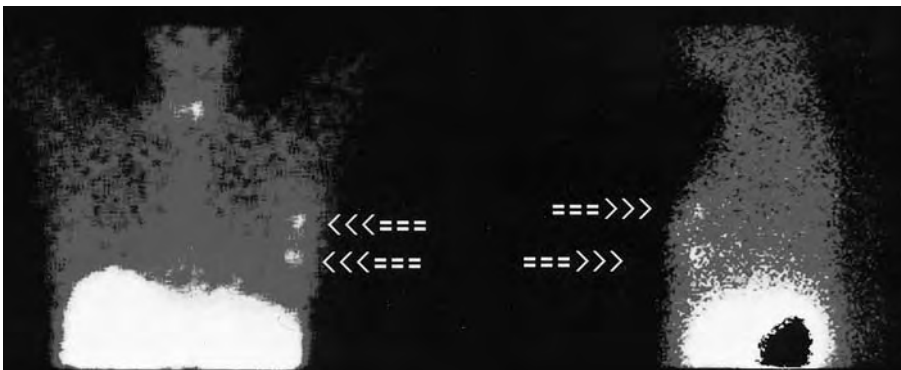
¹¹¹In-DTPA-D-Phe¹-octreotide scintigraphy in a patient with breast cancer. The arrows indicate two tumor masses in the left breast. Planar images in anterior (left panel) and left lateral view (right panel)
